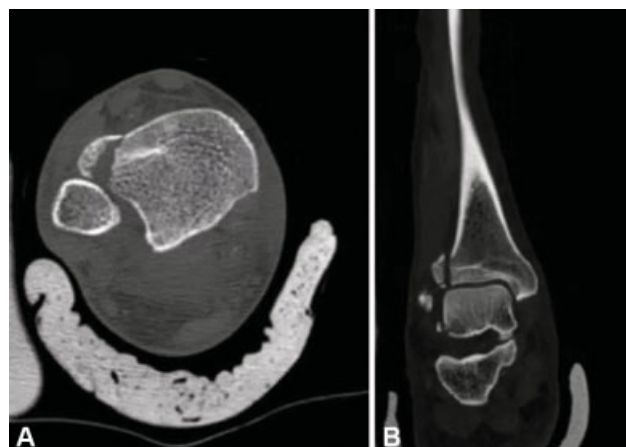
Computed tomography of right ankle. (A) Axial view; (B) Sagittal view.
